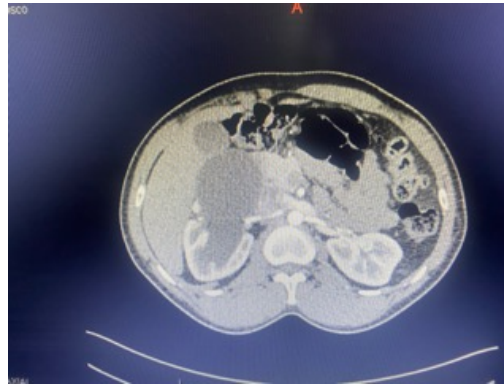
Abdominal CT scan showing a right pyelo-ureteral junction obstruction.
